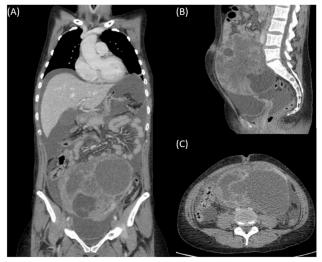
(A) Coronal CT image of the chest, abdomen and pelvis with IV contrast. A complex ovarian mass measuring approximately 20cm in diameter is visible. (B) Sagittal and (C) axial images show a hyperdense umbilical nodule measuring 2.5cm in diameter.
